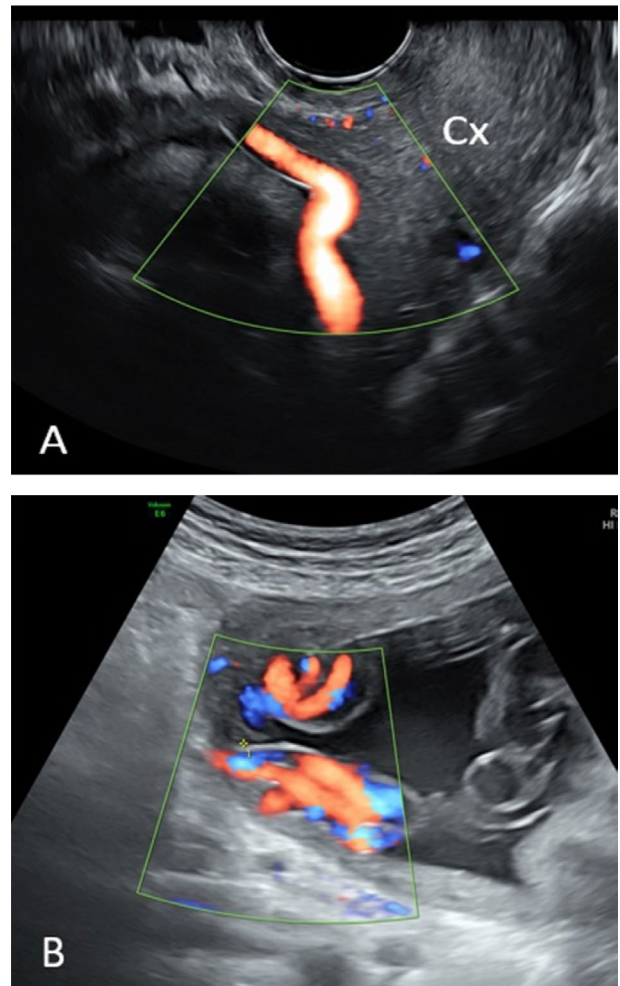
(A) Pregnancy at 27 weeks' gestation. Marginal placental cord insertion using color Doppler ultrasound. (B) Spatio-temporal image correlation with HD-Flow in “glass body” rendering mode allows us to accurately display the distance between the insertion of the umbilical cord and the placental edge.
